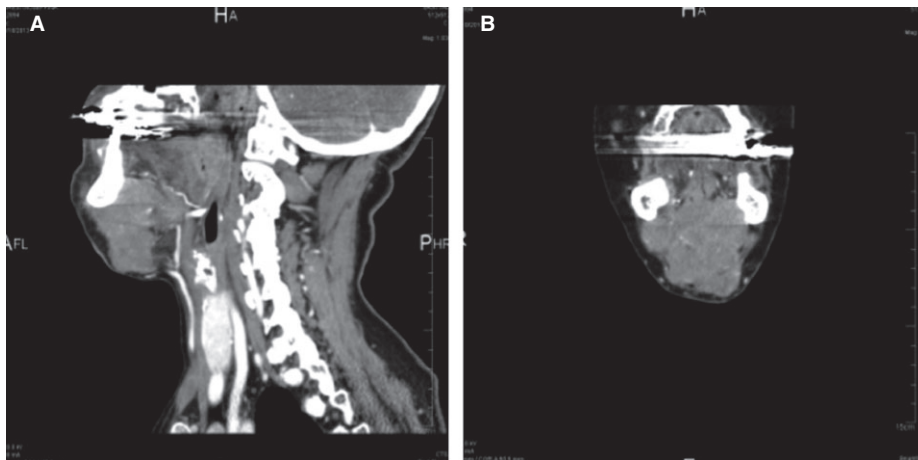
(A, B) Coronal CT scan images with contrast enhancement show a multilocular radiolucent borderline lesion extended both in laterocervical and submental regions.
